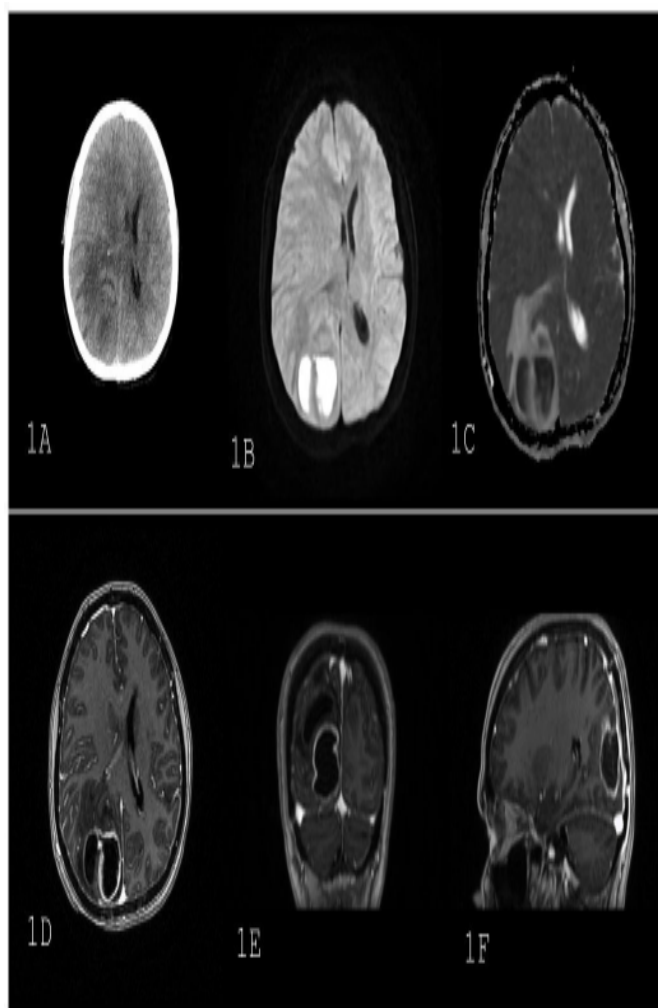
Preoperative brain CT shows a mass lesion located in the right occipital lobe, hypodense in the middle, surrounded by edema, and causing effacement of the right lateral ventricle. (1A). Diffusion MRI images show an area of diffusion restriction in the right occipital region (1B, 1C). Contrast-enhanced brain MRI images show widespread edema in the posterior section of the right cerebral hemisphere and an appearance consistent with a cystic mass lesion with contrast enhancement of the walls at this area level (1D, 1E, 1F)
